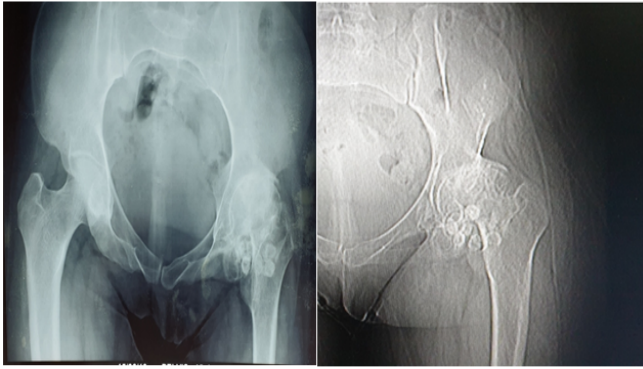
Preoperative radiographs of synovial chondromatosis.
